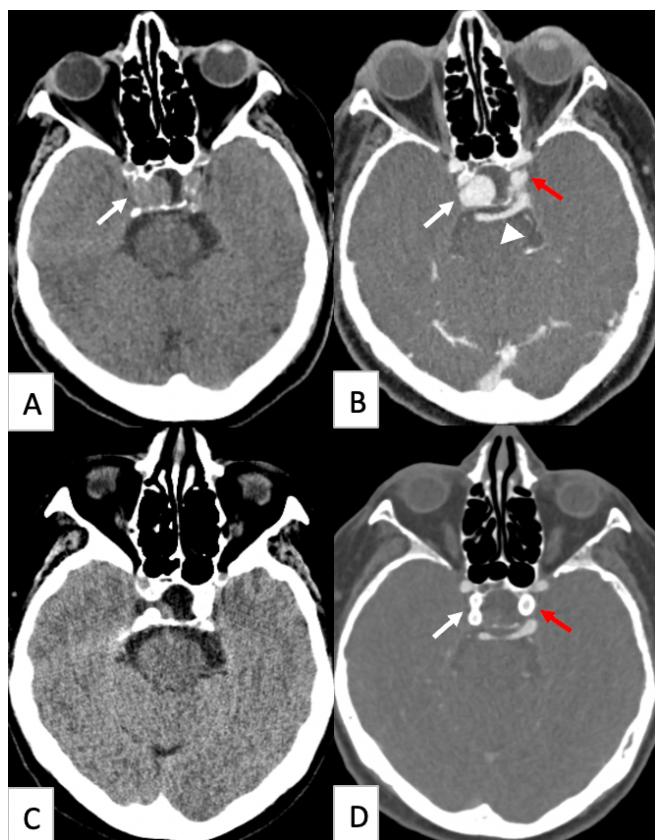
Preoperative (A-B) and first year (C-D) cranial CT and CT angiography axial images. A: White arrow shows the lesion in the right half of the sella confused with the pituitary mass. B: White arrow shows cavernous segment aneurysm of the right internal carotid artery, triangular head shows PPTA and red arrow shows PPTA aneurysm. C: Postop first year control cranial CT, D: Postop first year control cranial CT angiography
